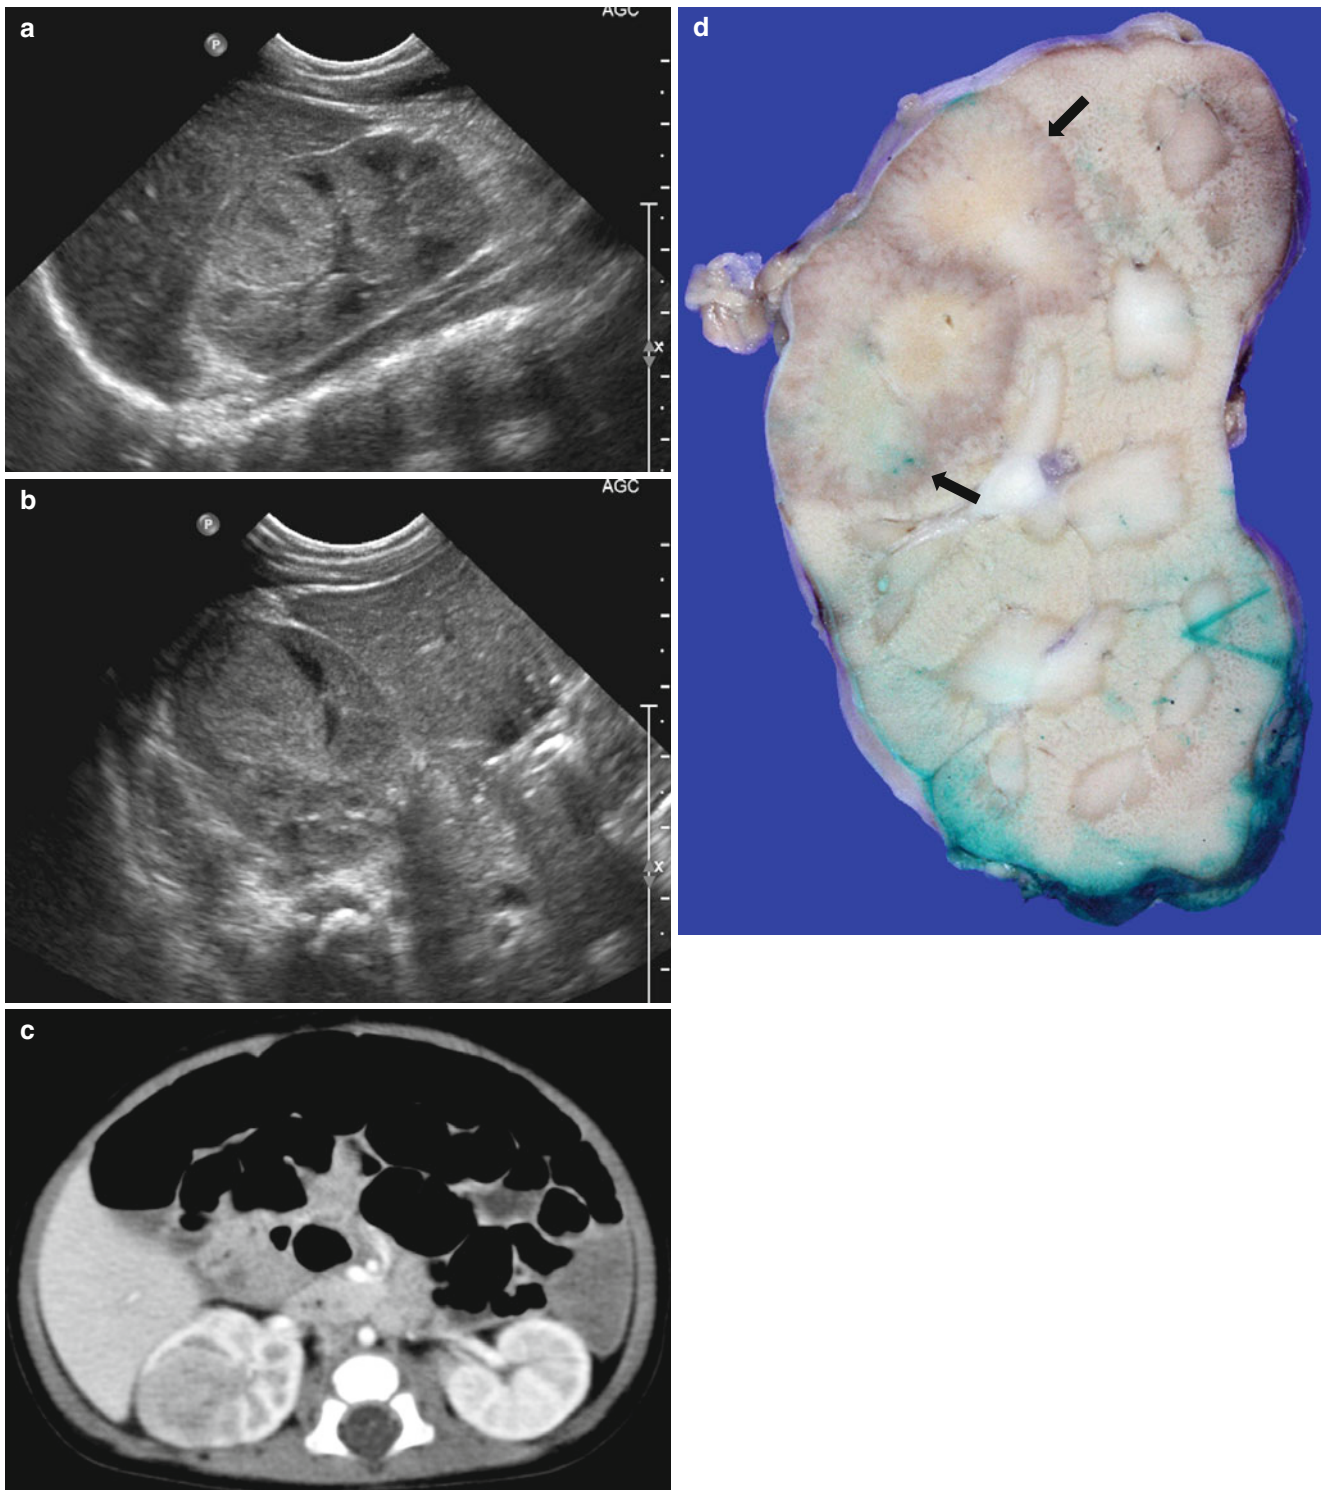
Xanthogranulomatous pyelonephritis.* Sagittal (a) and transverse (b) US of the right kidney show round, hyperechoic mass-like lesion containing hypoechoic portions. Contrast-enhanced CT (c) shows poorly enhancing mass-like lesion in the right kidney. Gross
